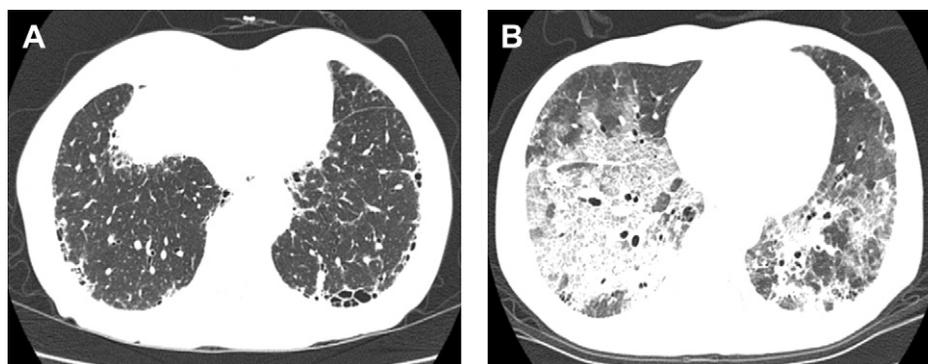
CT findings of Interstitial Pneumonia Associated with MPO-ANCA Patient 2 (A) showed relatively large sized cyst and honeycomb change at subpleural predominance in the lung base. Patient 8 (B) demonstrated reticulo-nodular shadows as a background finding superimposed of diffuse ground glass opacity corresponding to acute exacerbation.
